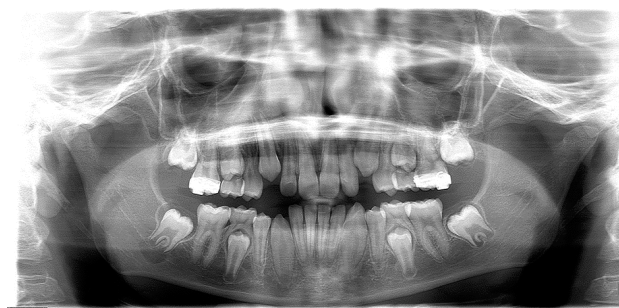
On panoramic radiograph, radiolucency below the developing right second molar (open apices)
